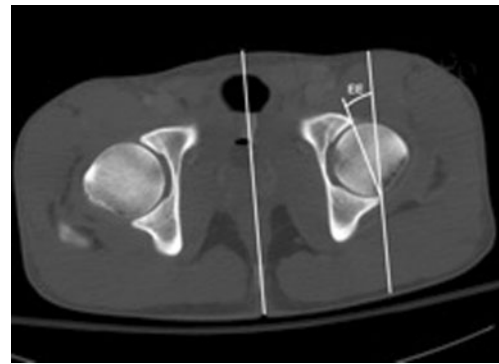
Axial CT scan at the level of maximum femoral head diameter: the equatorial edge (*EE*) angle indicates the acetabular version. In this case wide anterior opening results in a positive value ($+16^\circ$)
